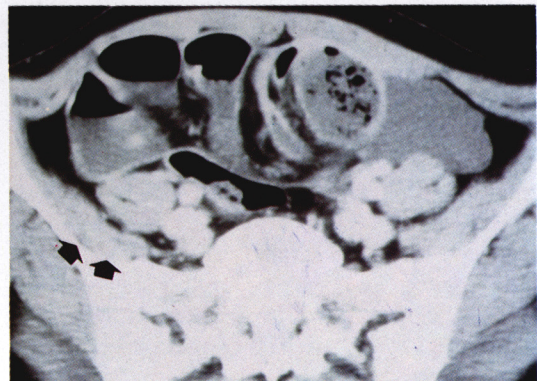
CT scan of the lower abdomen shows the clustered gas-containing small bowel loop and dilated proximal small bowel with air-fluid levels due to intestinal obstruction. A small amount of ascites is seen in the left inguinal fossa(arrow).
